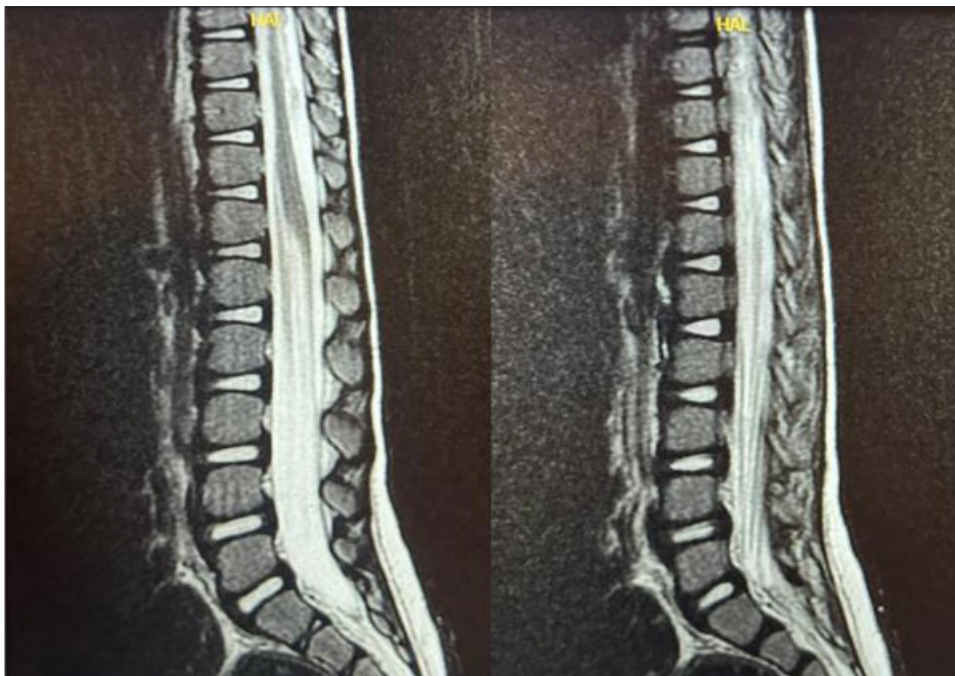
Magnetic resonance imaging demonstrated thickening of the anterior cauda equina nerve roots.
